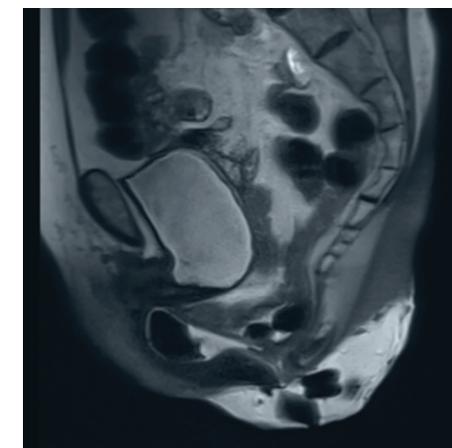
Sagittal T2 "dynamic" MRI image with Valsalva showing large enterocele.
